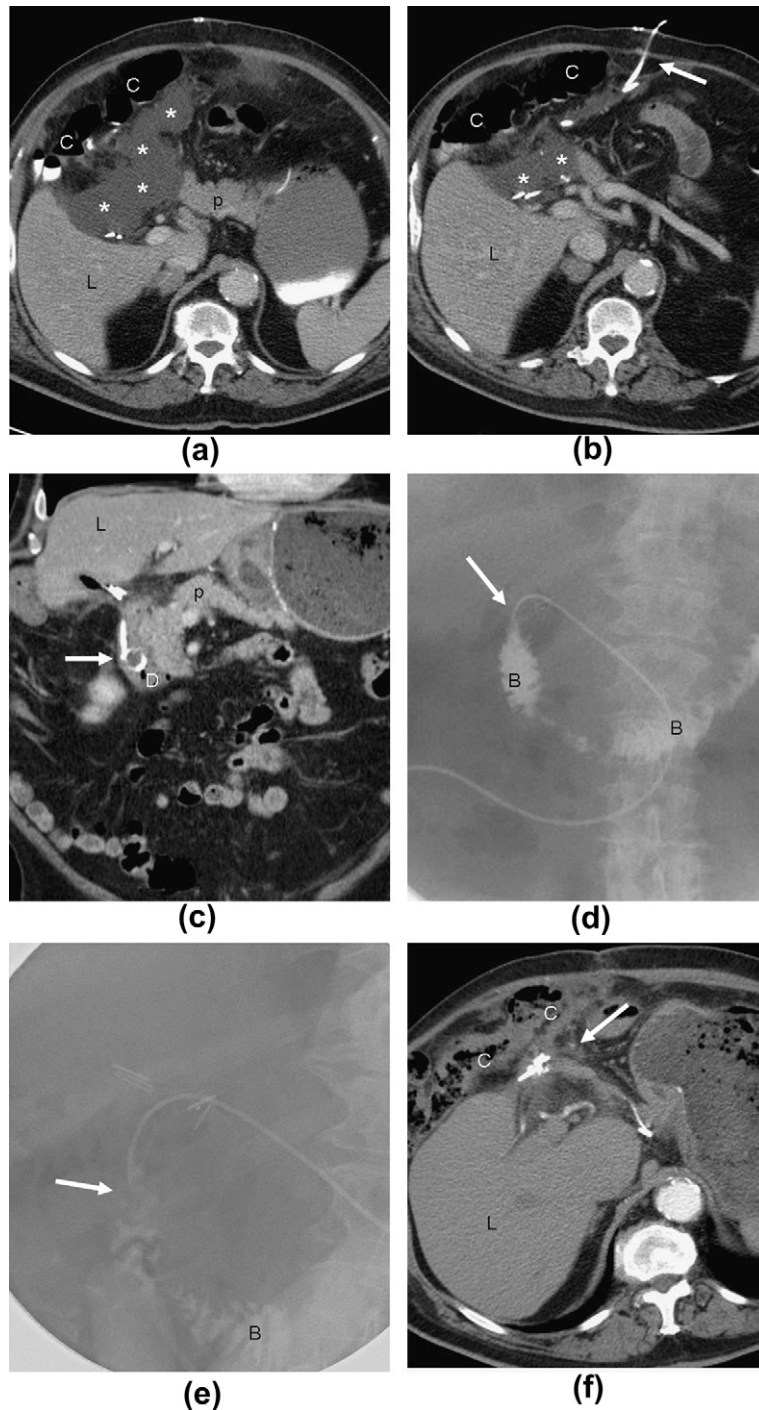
Treatment of an enteric fistula in a patient who underwent subtotal gastrectomy for gastric cancer. (a) A CT image 7 days after surgical resection demonstrated fluid collection (asterisks) between the pancreas (*P*), liver (*L*), and transverse colon (*C*). (b) A percutaneous drainage catheter (arrow) was inserted into the collection (asterisks) under CT guidance. *L*, liver; *C*, colon. (c) Fifteen days after insertion, a CT examination demonstrated the resolution of the fluid collection and migration of the tip of the catheter (arrow) into the duodenum (*D*). *P*, pancreas. (d) Contrast medium injection through the percutaneous drainage catheter (arrow) determined direct opacification of the bowel lumen (*B*). (e) Glubran2 was injected under fluoroscopic guidance at the level of the fistula (arrow) and the drainage catheter was removed. *B*, bowel. (f) CT image at 10 months showed complete resolution of the fluid collection (arrow). *C*, colon; *L*, liver.
